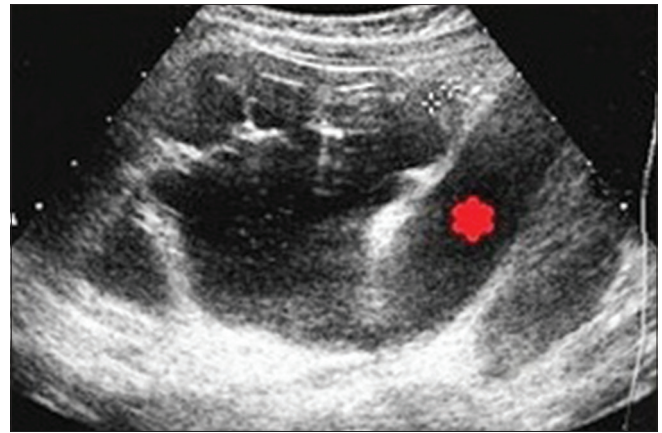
Fetal ultrasonography shows dilated distal ureter
